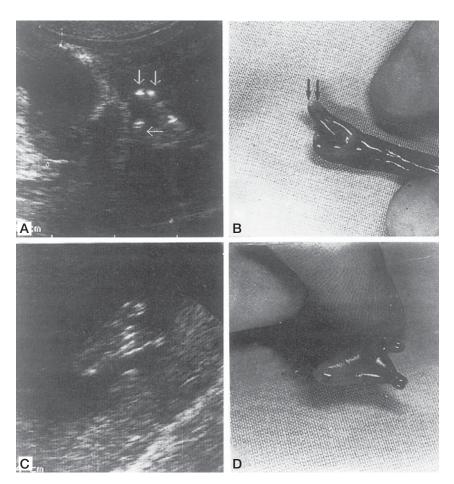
Corresponding transvaginal sonographic and pathologic views at 14 weeks of gestation of the fetal hand, demonstrating absent digits and symphalangism (panels A and B) and the fetal foot, showing absent digits and split foot malformation (panels C and D). (*Reprinted, with permission, from Bronshtein M, Gershoni-Baruch R. Prenatal transvaginal diagnosis of the ectrodactyly, ectodermal dysplasia, cleft palate (EEC) syndrome. Prenat Diagn. 1993;13:519-522. Copyright 1993 John Wiley and Sons. Reprinted, by permission, of John Wiley and Sons, Inc.*)
